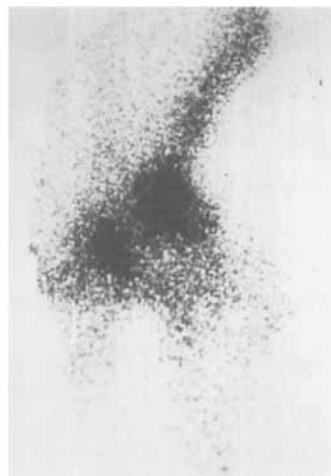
Types of scintigraphic images.
